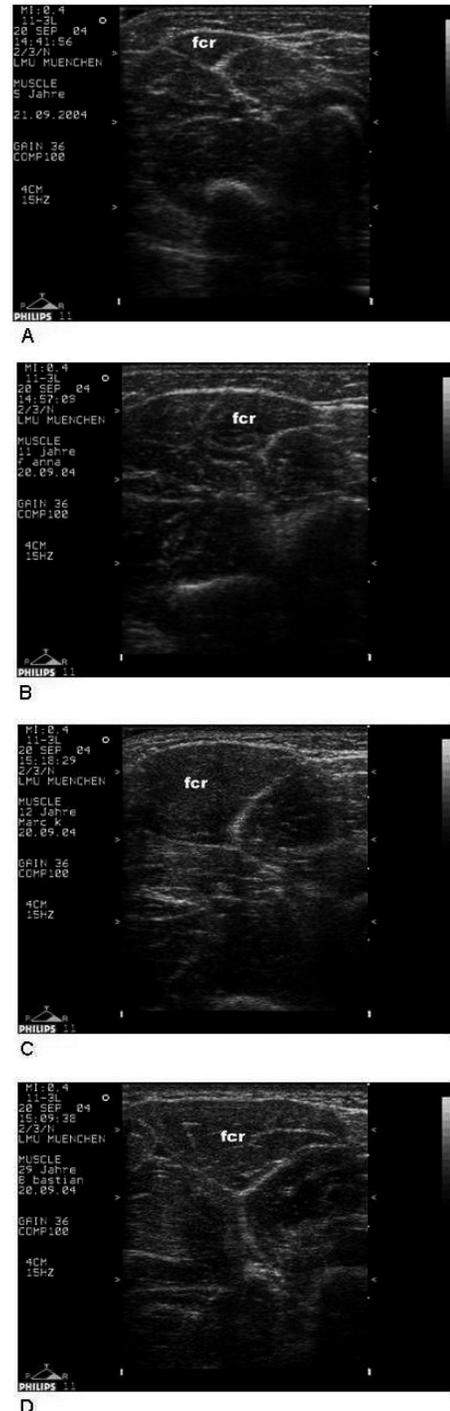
Transverse sectional ultrasound images of flexor carpi radialis muscle in healthy children and adults of different ages shown at identical ultrasound settings and probe position. Dependency of muscle size on age. A: 5 year old girl; B: 11 year old girl; C: 12 year old boy; D: 29 year old man.
